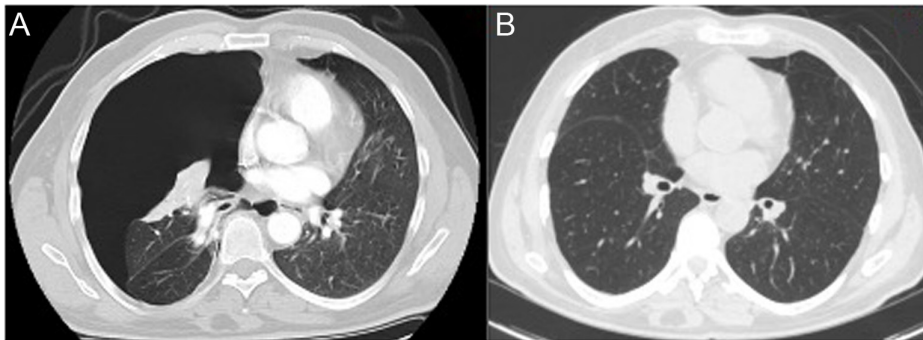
Thorax CT (A: pre-treatment, B: post-treatment).
